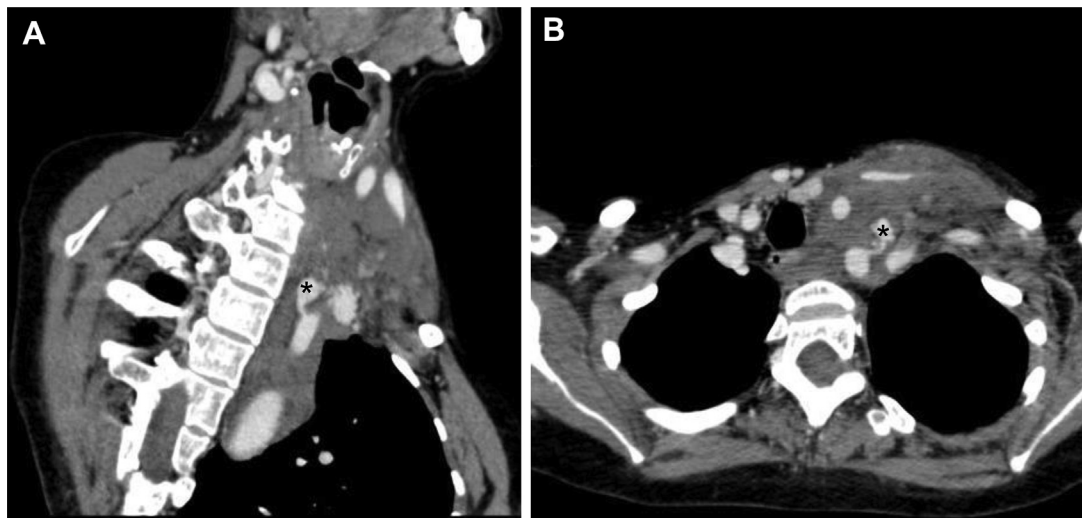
Computed tomographic angiogram performed directly after submission to the hospital. Massive hematoma of the left neck with a lateral shift of the trachea
